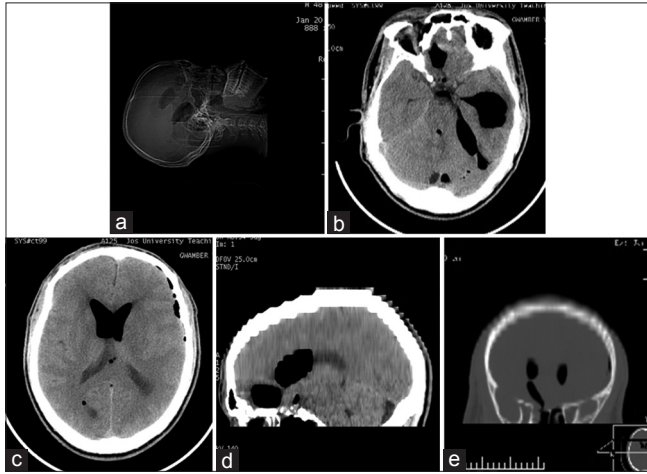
(a) Scanogram of Case 1 showing skull lucencies of pneumocephalus. (b) Axial computed tomography image showing pneumocephalus and left temporal horn tension pneumoventricles. (c) Pneumoventricle in lateral ventricles. (d) Sagittal reconstructed image of Case 1. (e) Bone window showing coronal section through the anterior ventricular horns and the cribriform plate, demonstrating skull base fracture and pneumocephalus/pneumoventricles in Case 1
